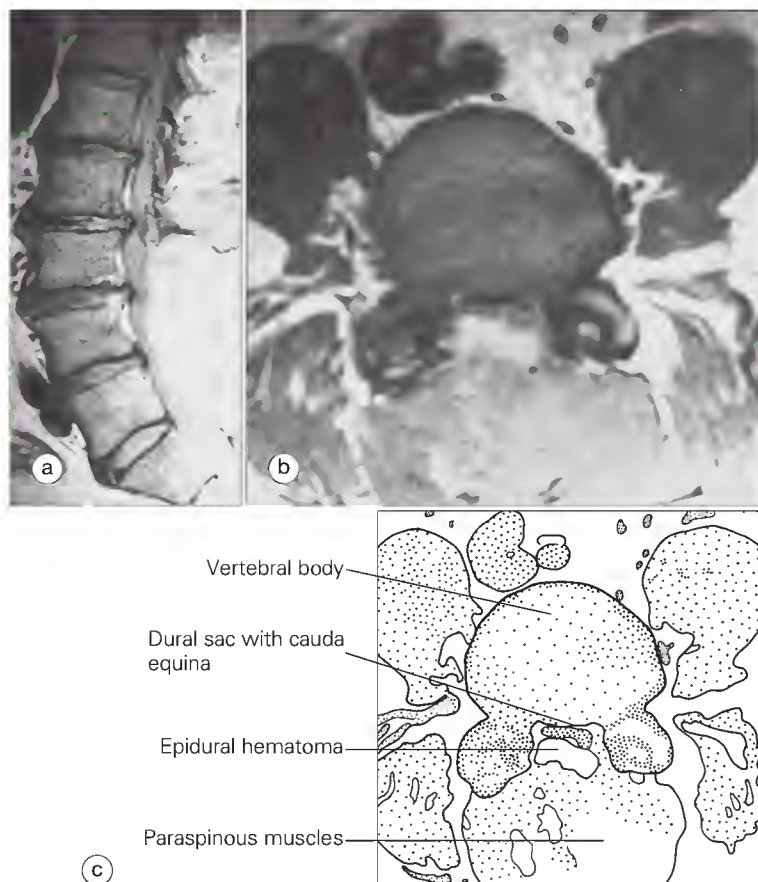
(a to c) Epidural hematoma. Postoperative sagittal and axial magnetic resonance imaging shows an epidural hematoma compressing the cauda equina.
